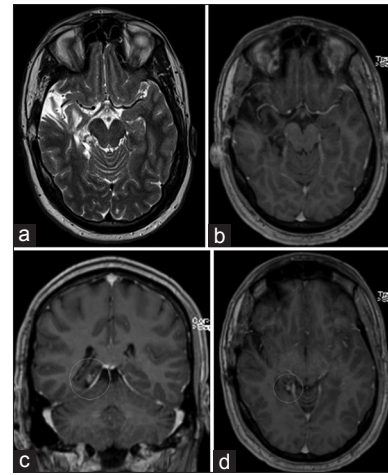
(a-d) MRI 2013: axial T2, axial and coronal T1 MR images show dramatic decrease in DNT size and contrast enhancement 8 years after GKRS
